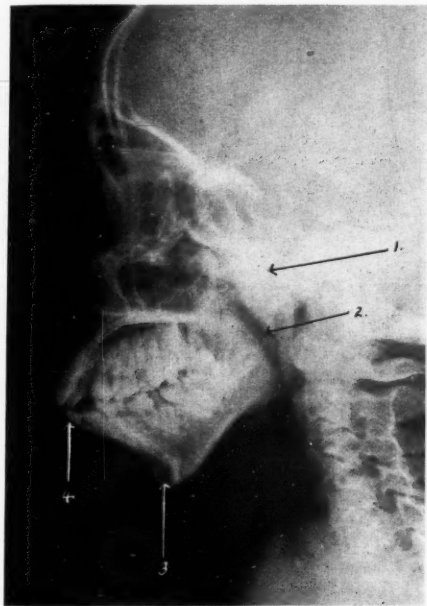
Radiographic appearances showing: (1) Ankylosis; (2) Short ramus; (3) Recession of chin; (4) Procumbent incisors.
